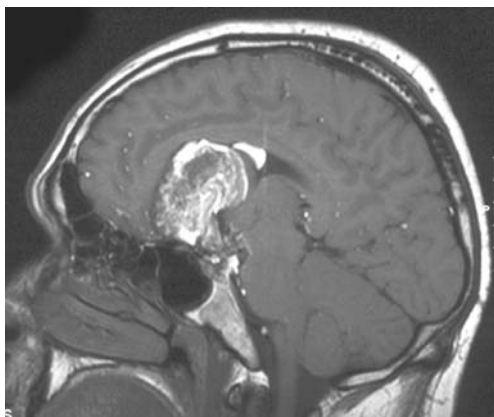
Sagittal MRI (T1-WI) of a suprasellar dermoid with fronto-temporal extension and subarachnoid spreading of fatty particles (Patient 2)
